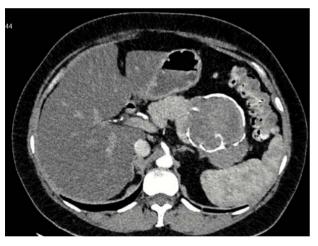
Abdominal CT scan. Heterogeneous image with lobulated contours and calcifications.
